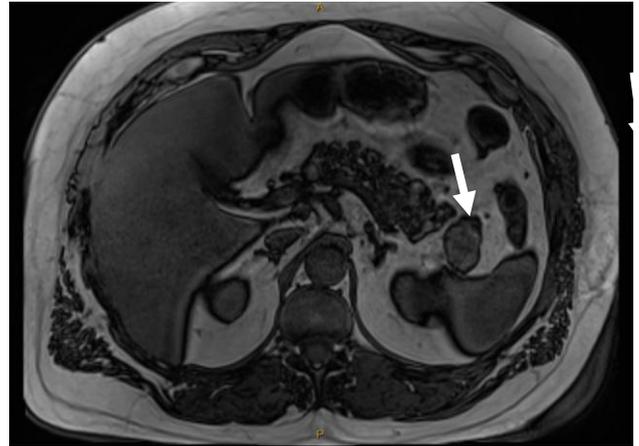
Axial T1-weighted MRI showing a well-circumscribed pancreatic tail lesion (arrow) that demonstrates signal intensity and internal configuration matching the adjacent splenic parenchyma, consistent with intrapancreatic accessory spleen.
